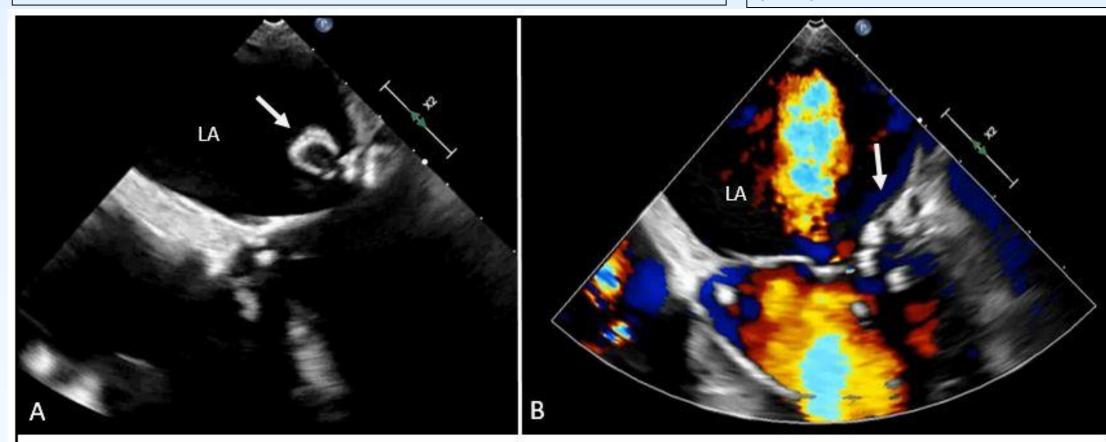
TEE showing 15 x 10 mm immobile cystic structure on the posterior mitral annulus (white arrow) in the left atrium (LA). Figure 1B. TEE with Doppler color flow mapping showing no blood flow to the cyst (white arrow) and moderate to severe mitral regurgitation.
